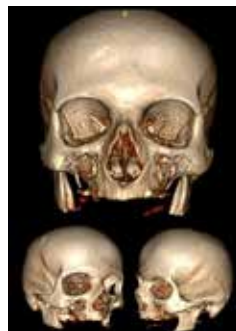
The control three dimensional CT imaging reconstruction presenting normal finding.
